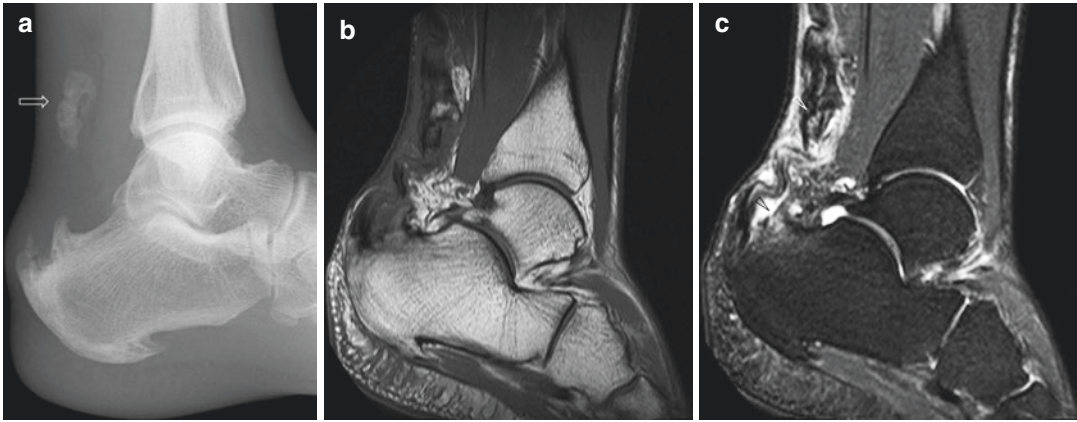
A 41-year-old woman who presented after a fall with left ankle pain and had significant limited range of motion. (a) Lateral radiograph of the ankle shows background calcaneal enthesopathy, with an avulsed fragment off the dorsal aspect of the calcaneus (*arrow*). This finding, together with concordant clinical examination findings, allowed the diagnosis of a high-grade
